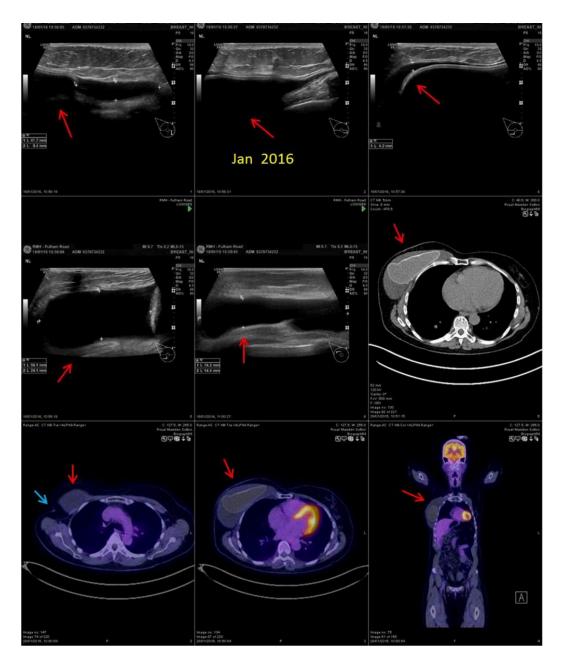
CASE 6 - 55-year-old lady. In 2000, she was diagnosed a right breast intraductal carcinoma in Stockholm, two lesions of 22 mm and 11 mm, respectively, grade 2, with 5/20 lymph node's extra-capsular spread. ER/PGR were positive. Therefore, right mastectomy associated with axillary nodal dissection was performed, followed by implant reconstruction and 8 cycles of chemotherapy (FEC) alongside radiotherapy to the ipsilateral breast/axilla. Furthermore, tamoxifen (6 years) and goserelin (5 years) were administered. In 2009 the implant was exchanged. In 2016 she had new sudden marked swelling of the right breast. IMAGING: On ultrasound, the implant on the right side appeared intact. There was a large volume of fluid (red arrow) around the prosthesis containing septations. No soft tissue abnormality demonstrated either in relation to the fluid collection or the overlying soft tissues. No evidence of free silicone within the reconstructed right breast or axilla. Diagnostic aspirate obtained from the cloudy
